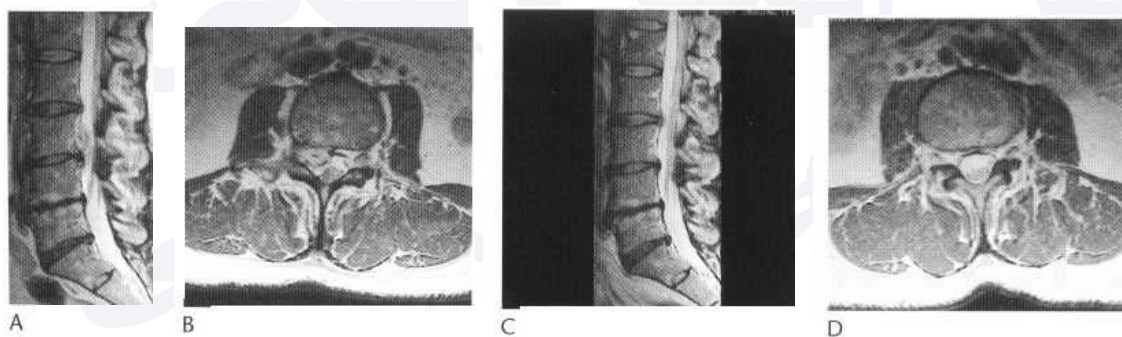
Extruded fragment from a degenerate L3/L4 intervertebral disc. (A,B) Sagittal and axial MRI with T₂
